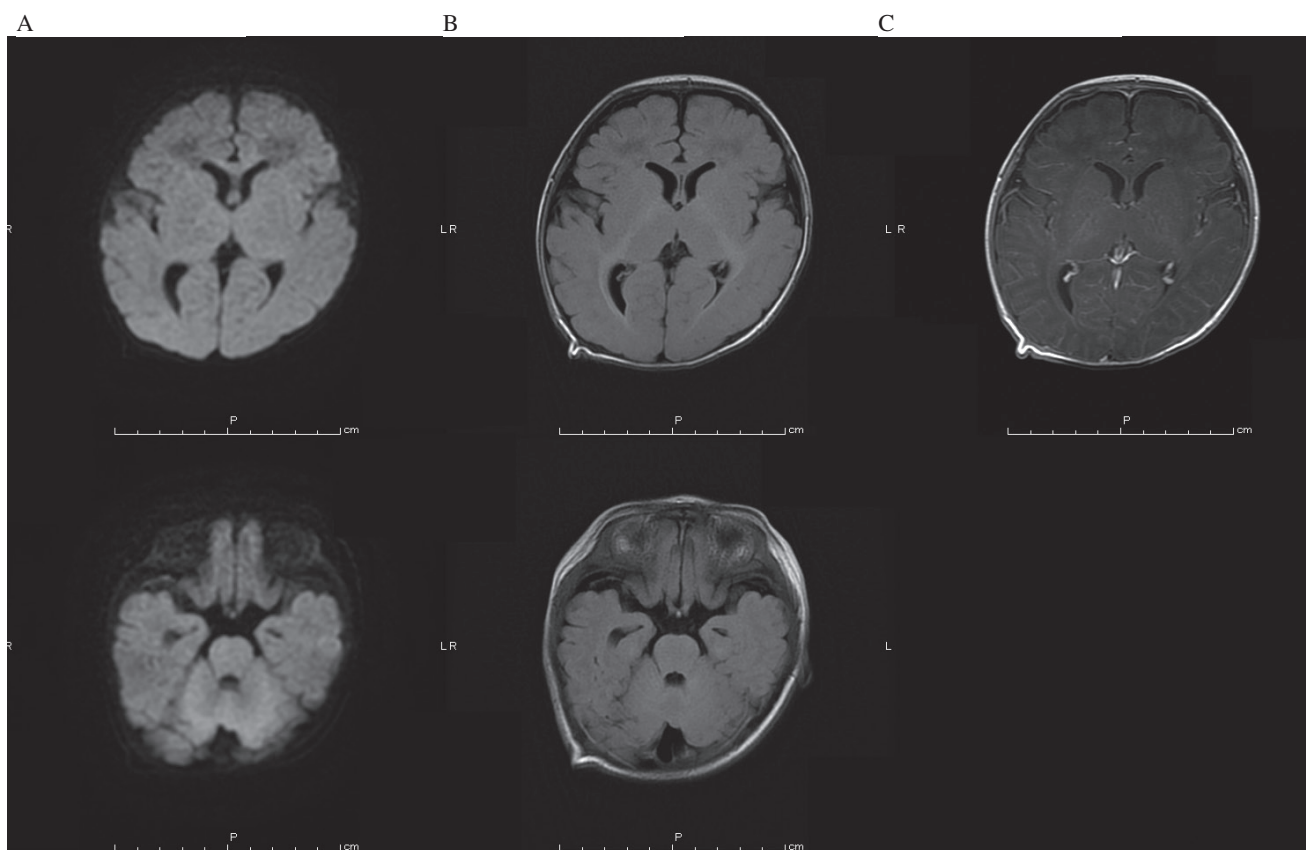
Head MRI on admission day22. (A) Diffusion-weighted imaging. (B) FLAIR imaging. (C) Gd-enhanced T1 weighted image. Abnormalities detected on MRI completely disappeared on admission day 22.
